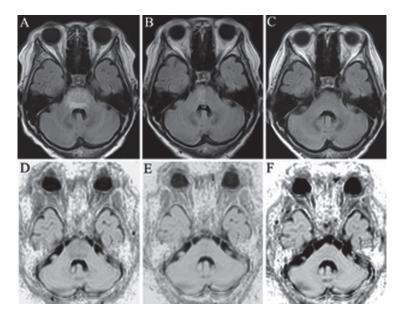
(A) Brain MRI on the first visit, showing mildly swollen pons, and inhomogeneous hyperintensities that mainly involved pontine longitudinal fasciculus and transverse pontine fibers on FLAIR imaging. (B) Brain MRI 2 months later, showing that the hyperintense lesions in the brainstem had diminished on FLAIR imaging. (C) The residual hyperintense lesions are completely resolved on FLAIR imaging 10 months after the first MRI. (D) The ADC value of the lesional area on the first MRI is 1.03×10^{-3} mm²/sec. (E and F) ADC values of the lesions on 2 months and 10 months after the first MRI are 0.83×10^{-3} mm²/sec and 0.79×10^{-3} mm²/sec, respectively. The changes of the ADC value can be easily recognized on the inverted images.
